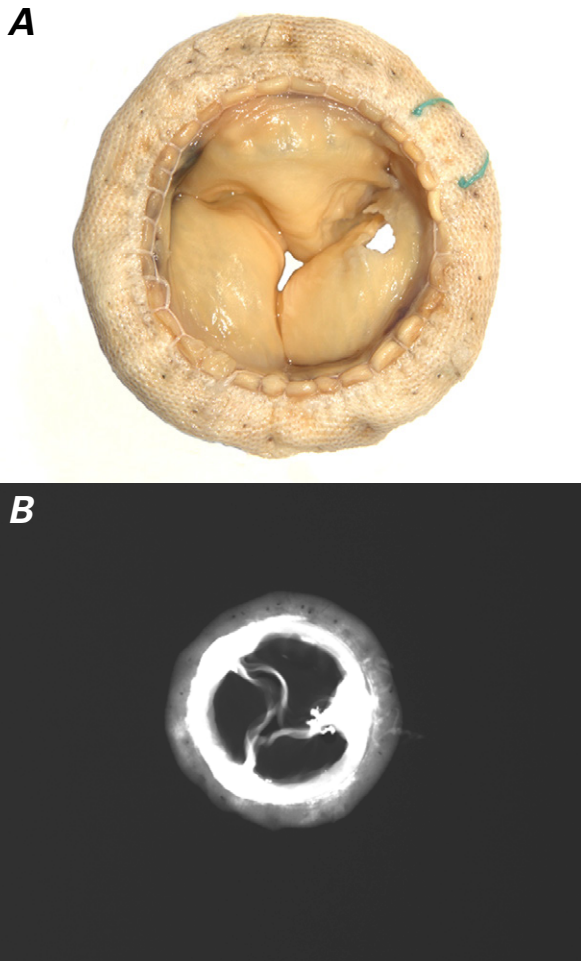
A) Photograph of a Mosaic bioprosthesis explanted at reoperation after 139 months shows dehiscence of one cusp. B) Radiographic image of the explanted prosthetic valve shows focal commissural calcification.
